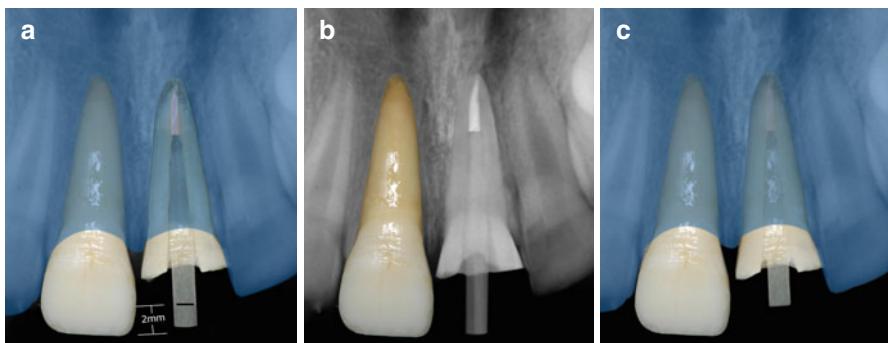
Post preparation. (a) Trying in the fiberglass post into the root canal. The fiberglass post should penetrate the whole length of the preparation. This can be checked with a radiograph (b). The fiberglass post is sectioned as described in Chap. 12 (Clinical case gently assigned by Prof. Leonardo Muniz; Muniz 2010; reprinted with permission)
